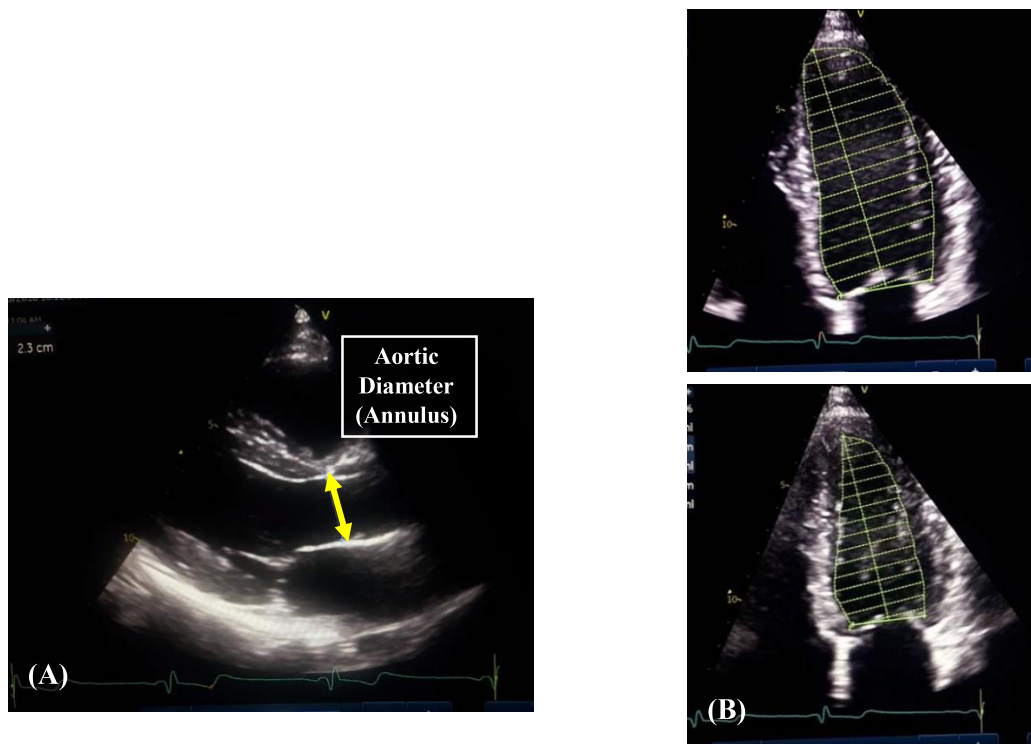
Echocardiographic Parameters. (A) Shows the measurement of Aortic diameter at the aortic annulus in the PLAX view. (B) Shows the measurement of LV ejection fraction using biplane (Simpson's) method (only apical 2-chamber view shown)
